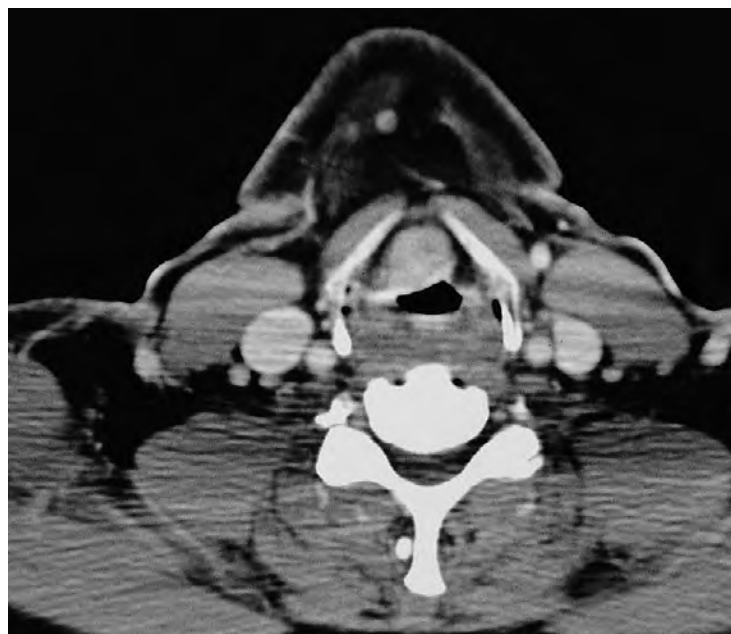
CT scan showing one lesion on the aryepiglottic fold (*left arrow*) and a second lesion on the lateral wall of the pyriform sinus (*right arrow*).
